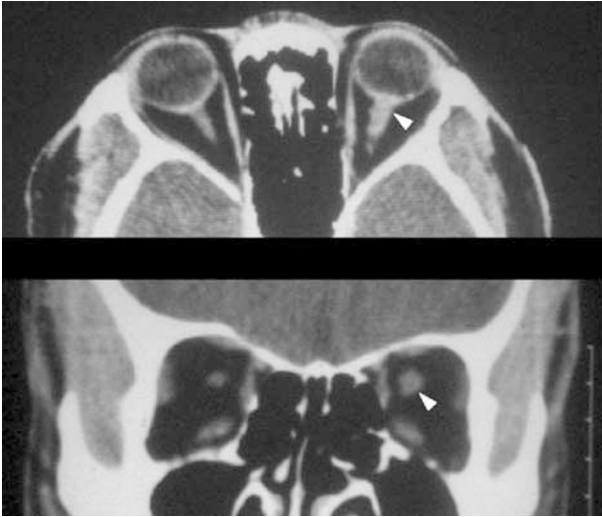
Case 1. Computed tomography showed an enlarged optic nerve of the left eye.
